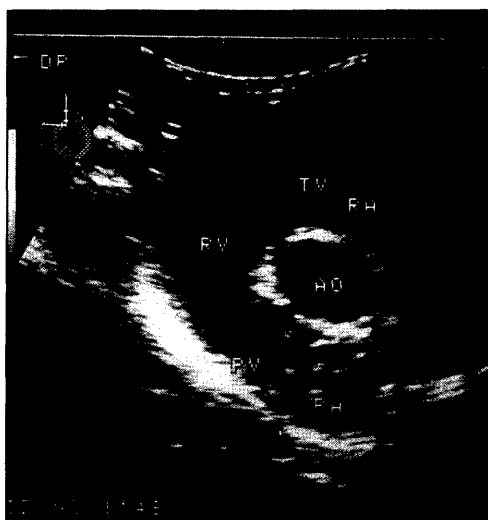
Two-dimensional echocardiogram before milbemycin D administration. TV: Tricuspid valve, RA: Right atrium, RV: Right ventricle, AO: Aorta, PV: Pulmonary valve, PA: Pulmonary artery.
